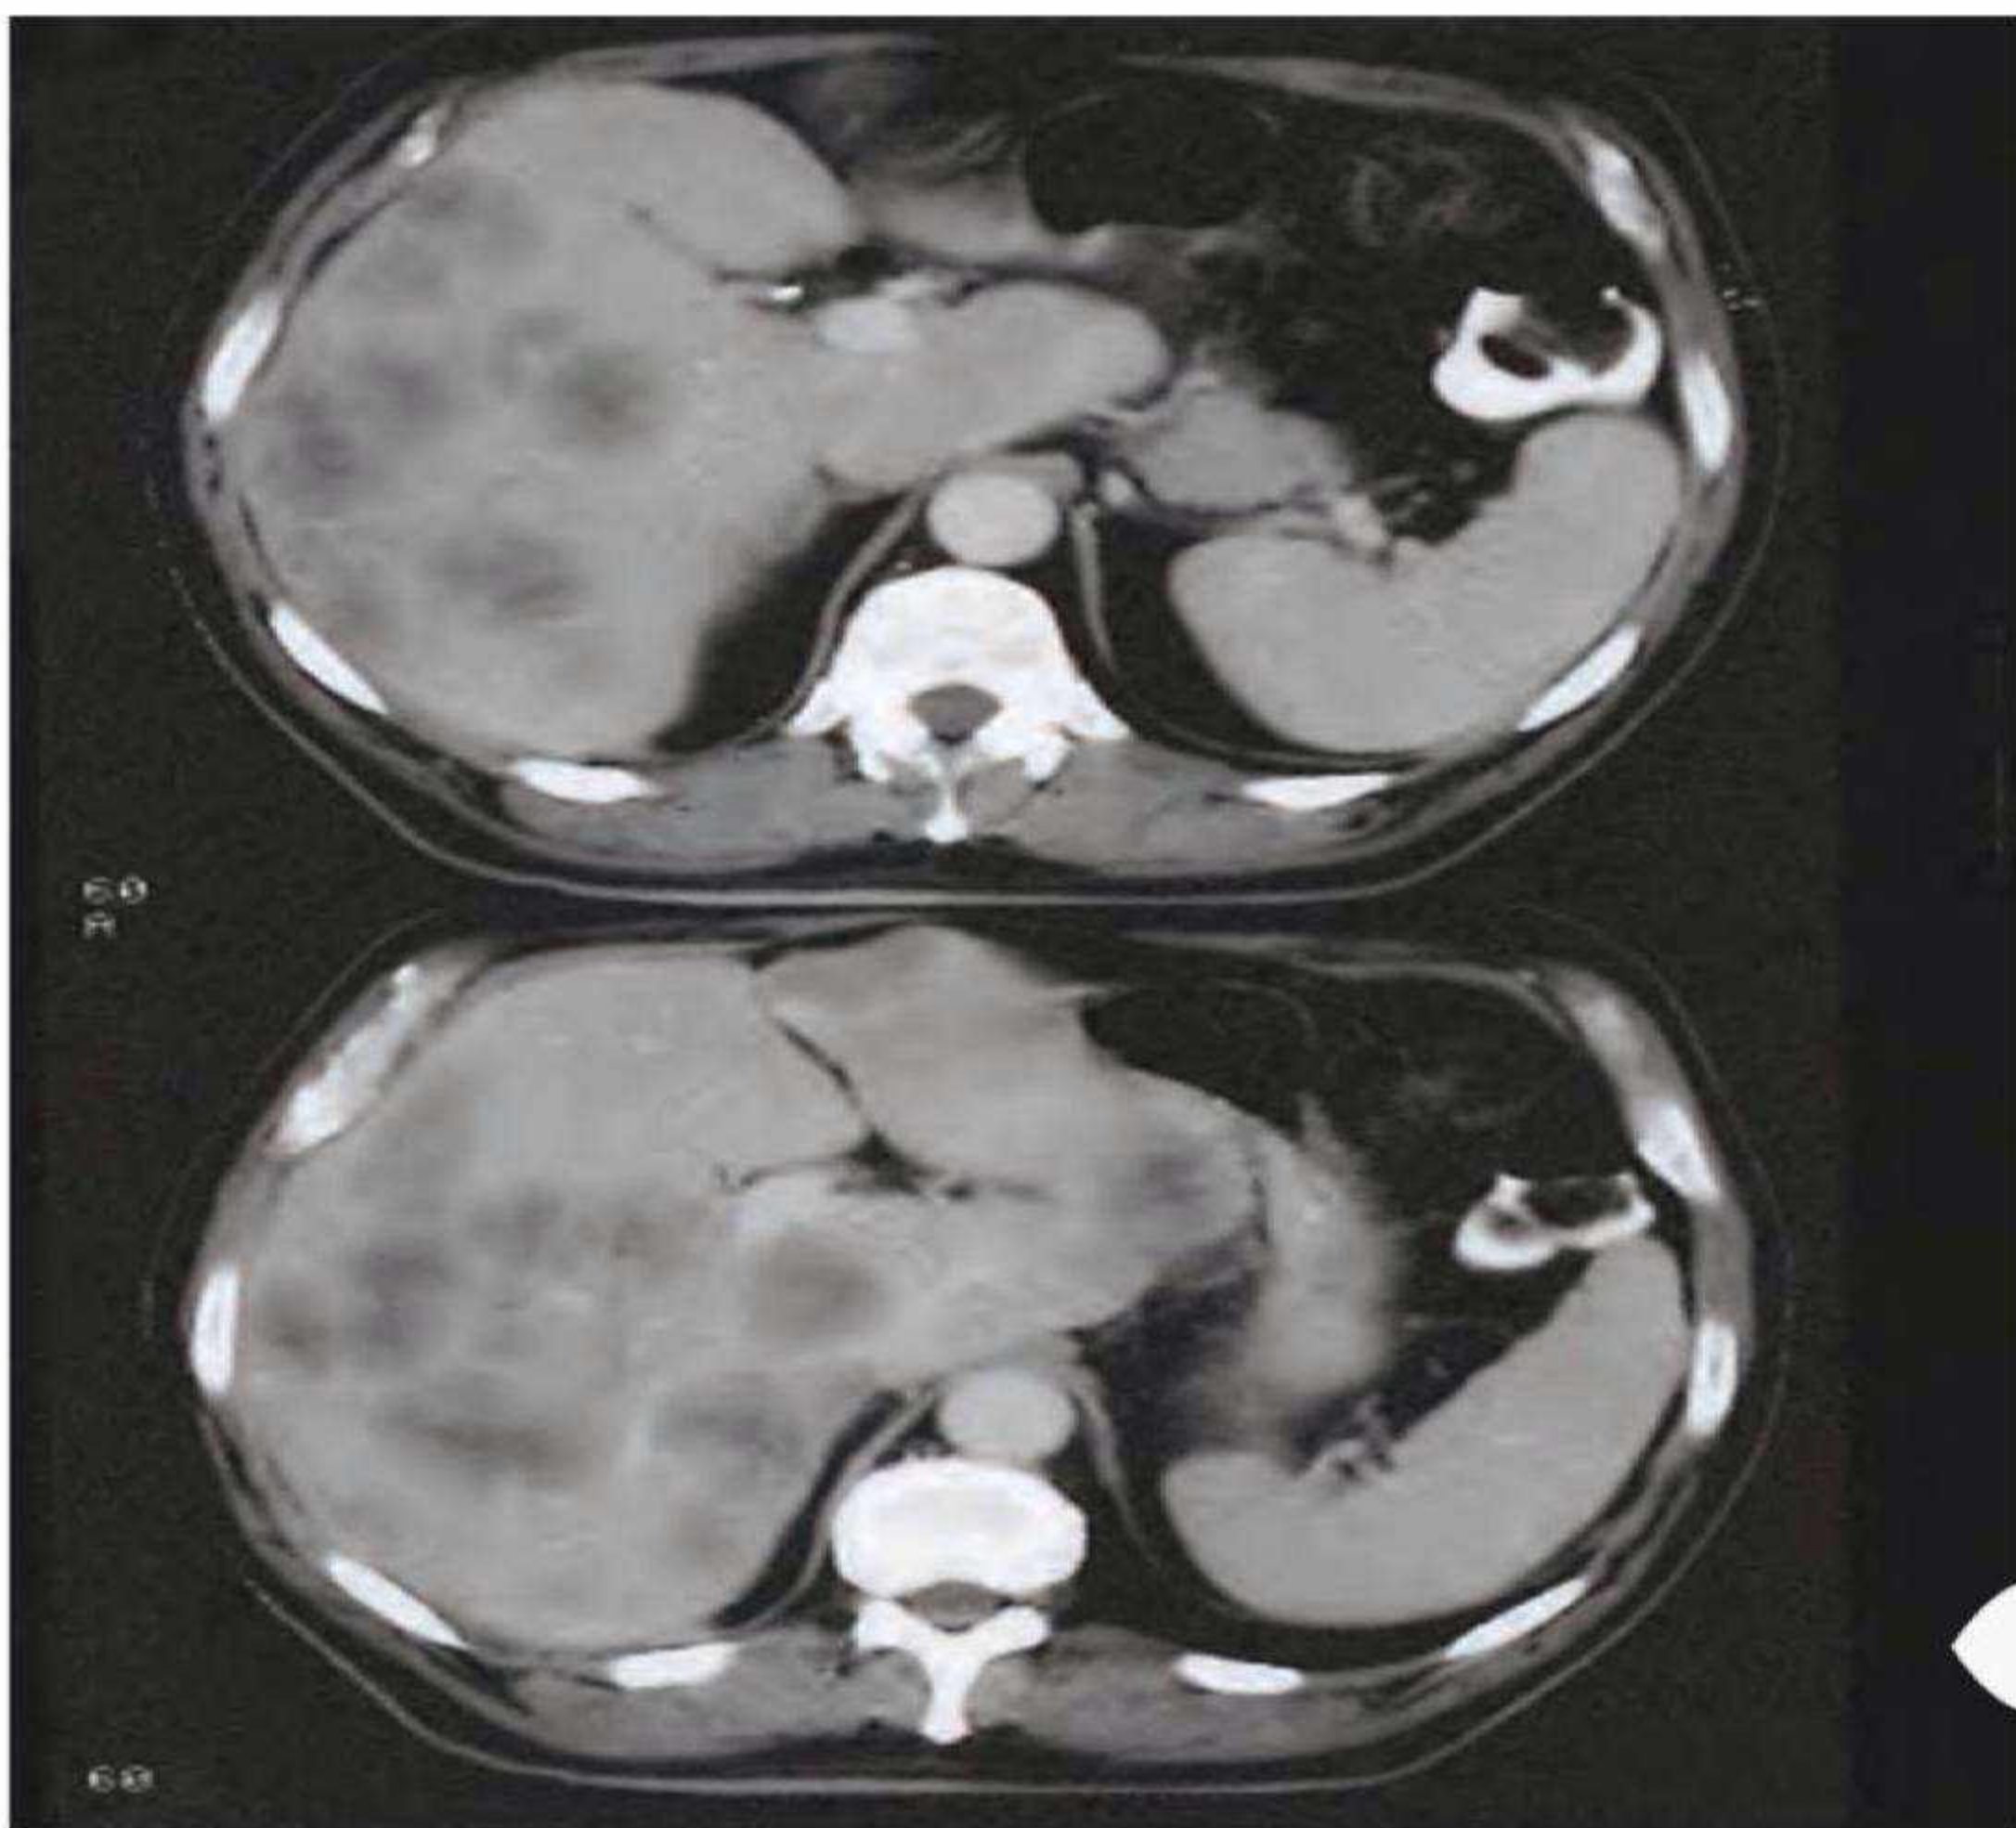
Computed tomography scan of the liver showing multiple metastases from carcinoma of the colon.
